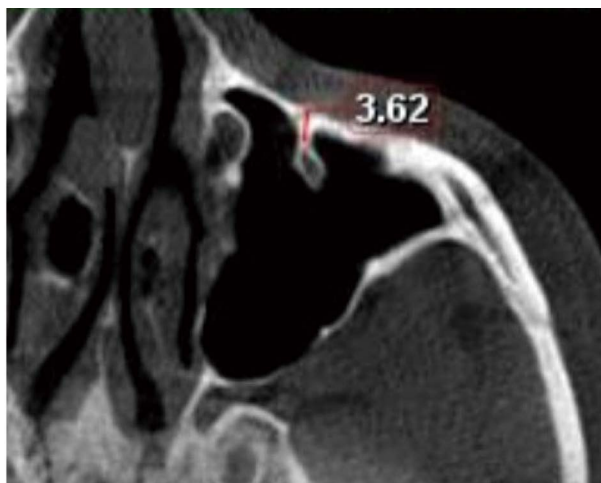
Axial cone-beam computed tomographic image shows the horizontal suspension of the infraorbital canal with a displayed septal length of 3.6 mm, denoting a class II canal (septal length >3 and ≤7 mm).
